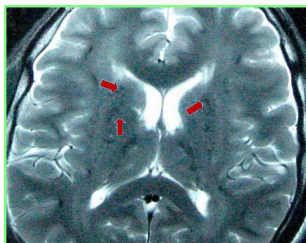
60 year old male with Fahr's syndrome. MRI axial T2 images at the of low ventricular level showing hypointense area (calcification) in the region of the basal ganglia (arrow). MRI: 1 Tesla magnet, T2 axial image (TE= 94, TR= 9000), 5 mm slice
